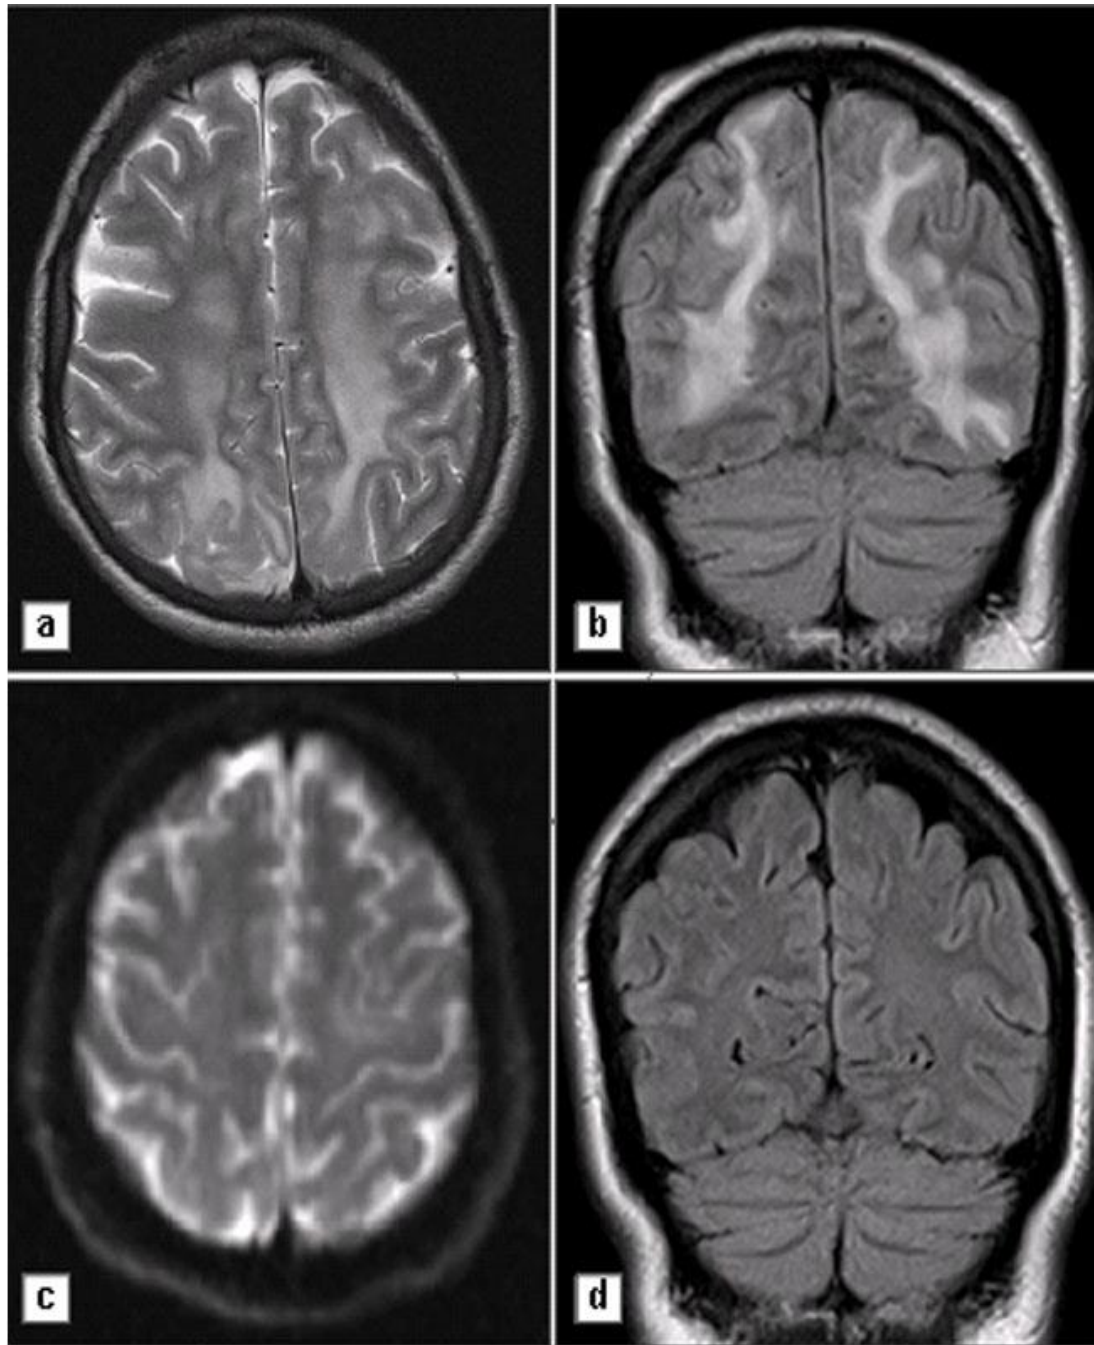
(a) T2-weighted axial image shows diffuse hyperintense signal in deep white matter and subcortical white matter in bilateral frontal and occipital regions. (b) Coronal FLAIR image shows diffuse hyperintense signal in deep white matter and subcortical white matter along the frontal and occipital regions. (c) Diffusion weighted image shows no evidence of diffusion restriction. (d) Follow-up Coronal FLAIR image shows complete resolution of previously noted abnormal signals.
